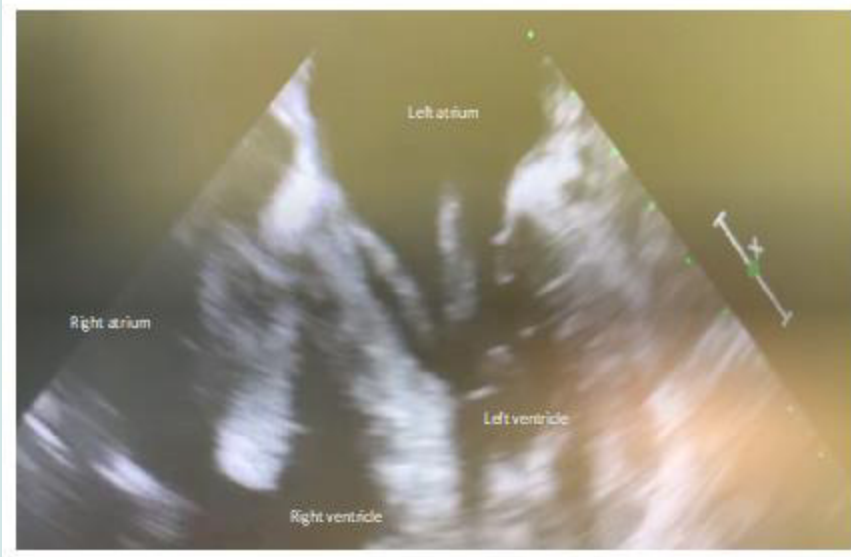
Echocardiogram noting mobile clot extending through both tricuspid and mitral valve.
